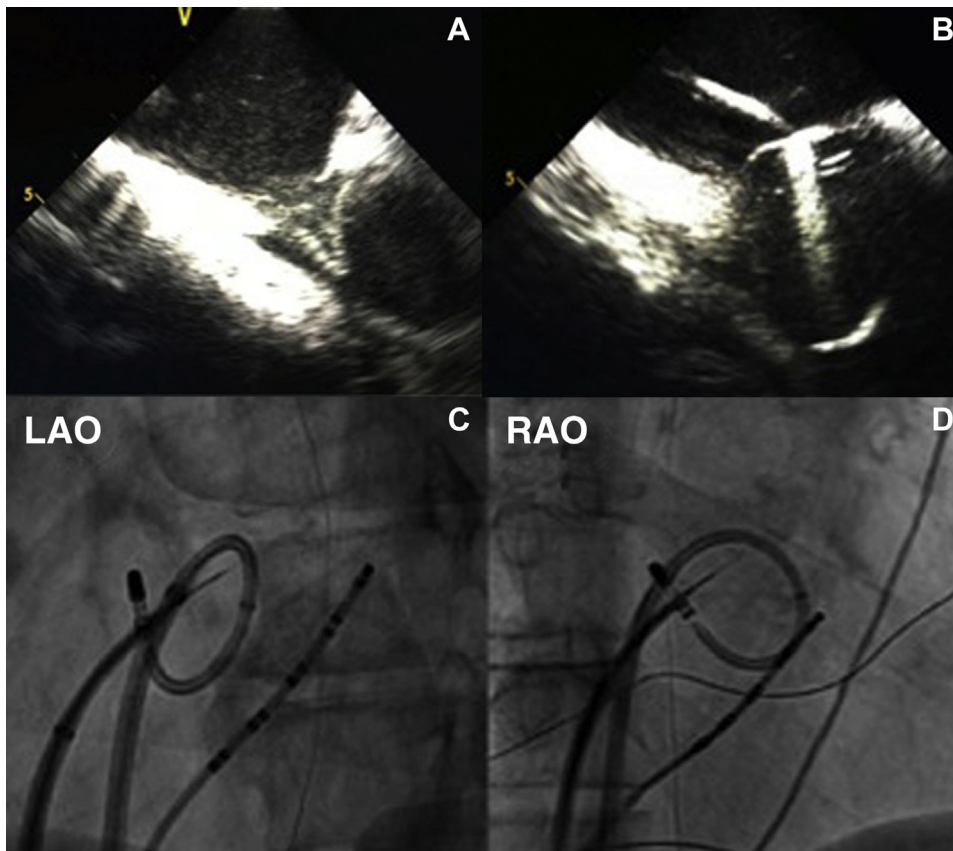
A: Intracardiac echocardiographic image showing marked tenting of the intra-atrial septum against the needle during the first transseptal puncture. B: Intracardiac echocardiographic image showing prolapsed ablation catheter tip artifact at the membranous fossa ovalis causing “reverse tenting.” Left anterior oblique (LAO) (C) and right anterior oblique (RAO) (D) images after the second transseptal puncture showing the curved ablation catheter against the intra-atrial septum and injected contrast within the left atrium well away from the free wall.
